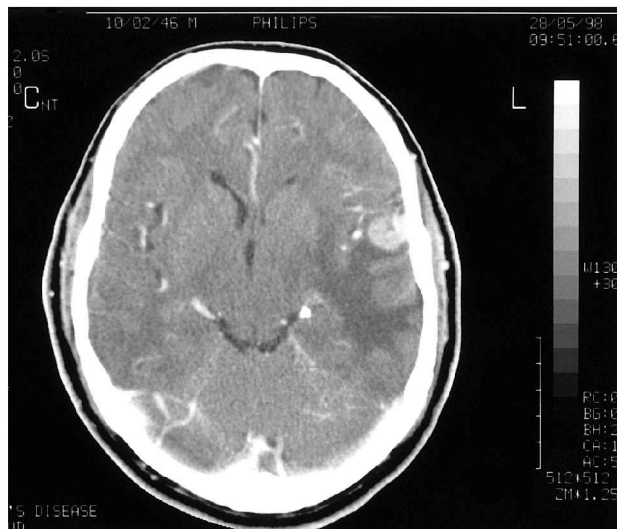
Contrast-enhanced CT scan of the head, demonstrating a parenchymal lesion in the left temporoparietal region.
